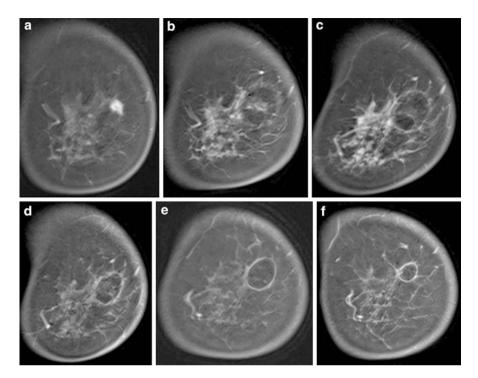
(a) Representative preoperative magnetic resonance imaging (MRI) demonstrating an irregular 10×8 mm-sized enhanced mass without surrounding intraductal extension. (b) One month after radiofrequency ablation (RFA), a slightly enhanced region can be observed within the rounded ablation zone. The left region outside the ablation zone is a hyperintense area. This site is not present within the range of the tumor observed on preoperative MRI but rather represents marginal inflammatory cell infiltration outside the ablation zone. (c–e) MRI performed 6 months, 1 year, 3 years, and 5 years after RFA. The ablation zone has been further reduced to 6×5 mm in size, and a slightly enhanced region is absent within the ablation zone
